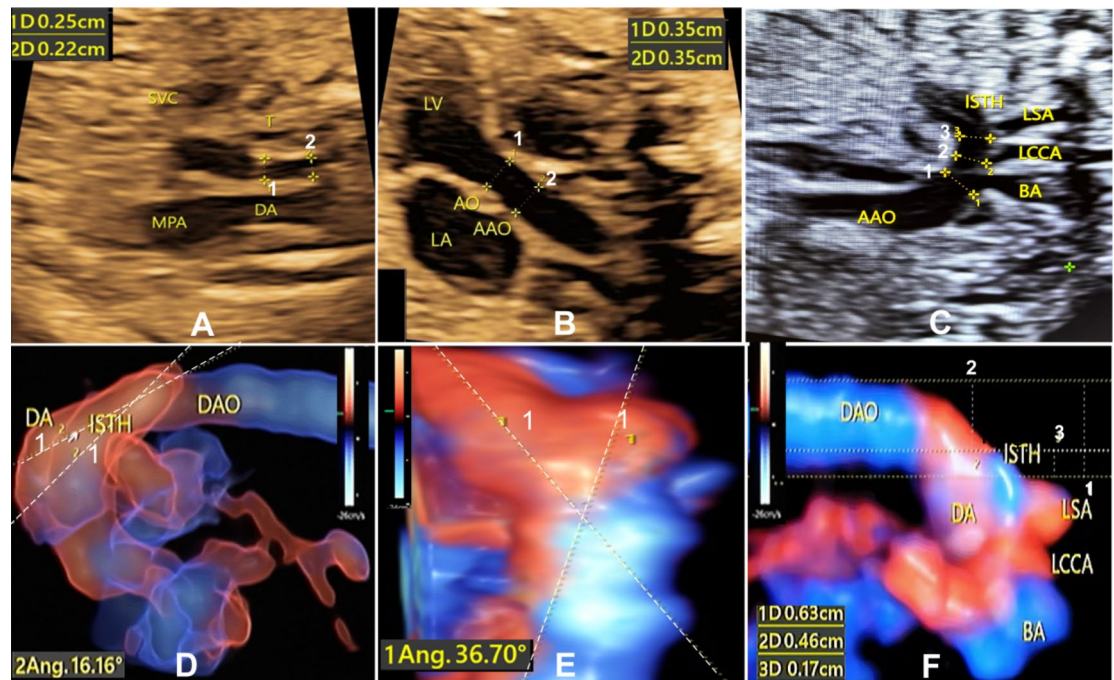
Parameters measured on ultrasound images. (A) The transverse aorta (1) and the aortic isthmus (2) diameters were measured on the 3 vessel trachea view, with the transverse aorta diameter of 0.25 cm and the isthmus diameter of 0.22 cm. (B) The aorta (AO) diameter at the aortic valve annulus and the ascending aorta (AAO) diameter were measured at the left ventricular outflow tract section, with the AO diameter (1) of 0.35 cm and the AAO diameter of 0.35 cm. (C) The aortic arch diameter was measured at arch 1 before the brachiocephalic artery (BA), arch 2 before the left common carotid artery (LCCA) and arch 3 before the left subclavian artery (LSA). (D) The DA-isthmus angle was measured on the HD Live Flow image on the sagittal view, with the DA-isthmus angle of 16.16°. (E) The DA-isthmus angle was measured on the 3D STIC HD Live Flow image viewed from the superior aspect, with the DA-isthmus angle of 36.70°. (F) Displacements 1–3 were measured on the 3D STICK-HD Live Flow image. Displacement 1: the vertical distance between the LSA origin and the outer edge of the descending aorta (DAO), displacement 2: the vertical distance between the aortic arch inlet point on the aorta (or isthmus-DA junction) and the DAO outer edge, and displacement 3: the vertical distance between the LSA origin and the isthmus-DA junction. DA ductus arteriosus; SVC superior vena cava; ISTH aortic isthmus.
